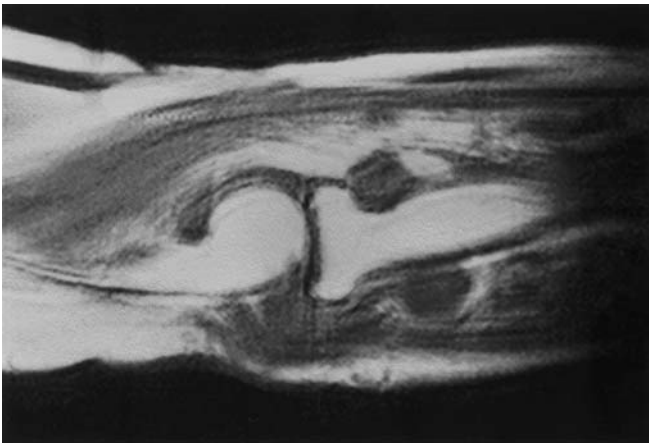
T1-weighted magnetic resonance imaging (MRI) scan
